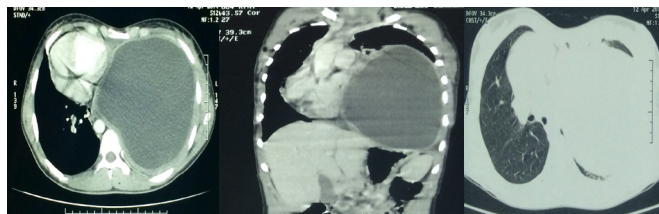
A) Axial soft-tissue view. Contrast enhanced computed tomography (CECT) shows a large cystic lesion containing fluid with attenuation values similar to water (Hounsfield unit) with well enhanced wall with shifting of the heart to the right and compressing atelectasis of the left lower lobe. B) Coronal soft-tissue view of CECT showing the craniocaudal extension of the cyst measuring $13 \text{ cm} \times 14.5 \text{ cm} \times 17 \text{ cm}$, with a mass effect pushing the heart to the right. C) Lung window showing compressing atelectasis of the left lower lobe.
